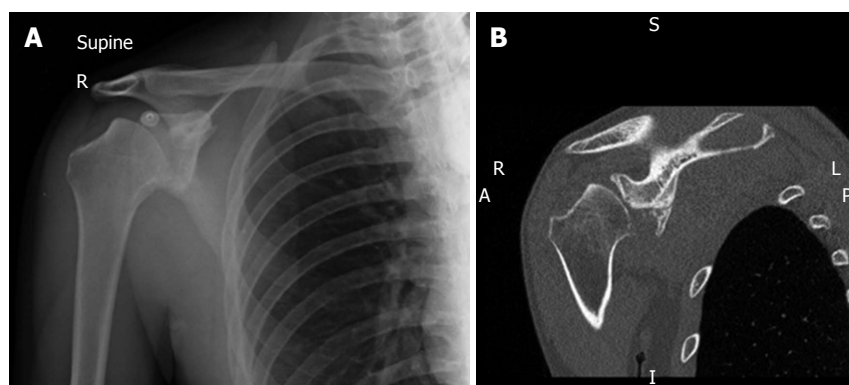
Antero-posterior radiograph (A) and computed tomography scan (B) of a 25-year-old epileptic with massive bipolar bone loss. He was found to have > 25% glenoid bone loss and > 40% humeral bone loss pre-operatively.
